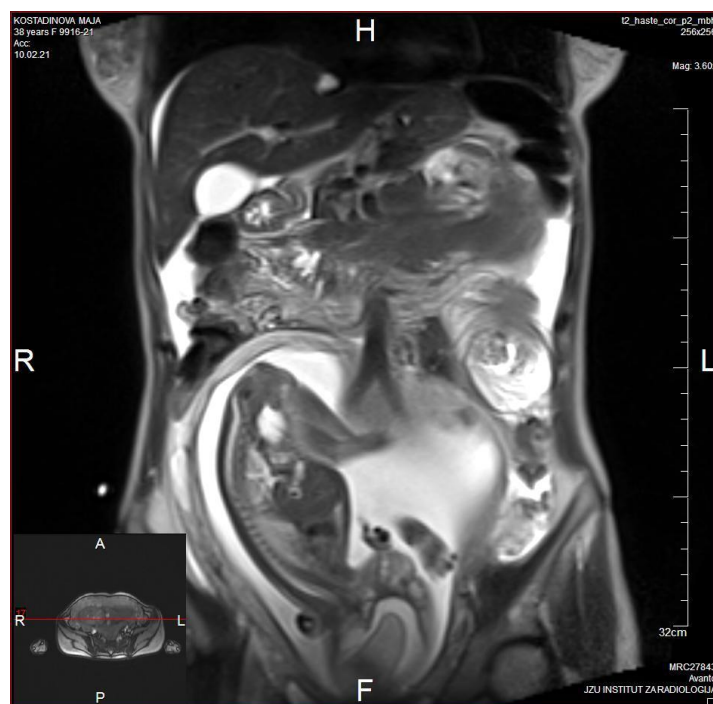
MRI of the abdomen, in front of the left kidney there is a tubular structure with diameter of 65 mm, in close relation with small intestine, in favour of intussusception
